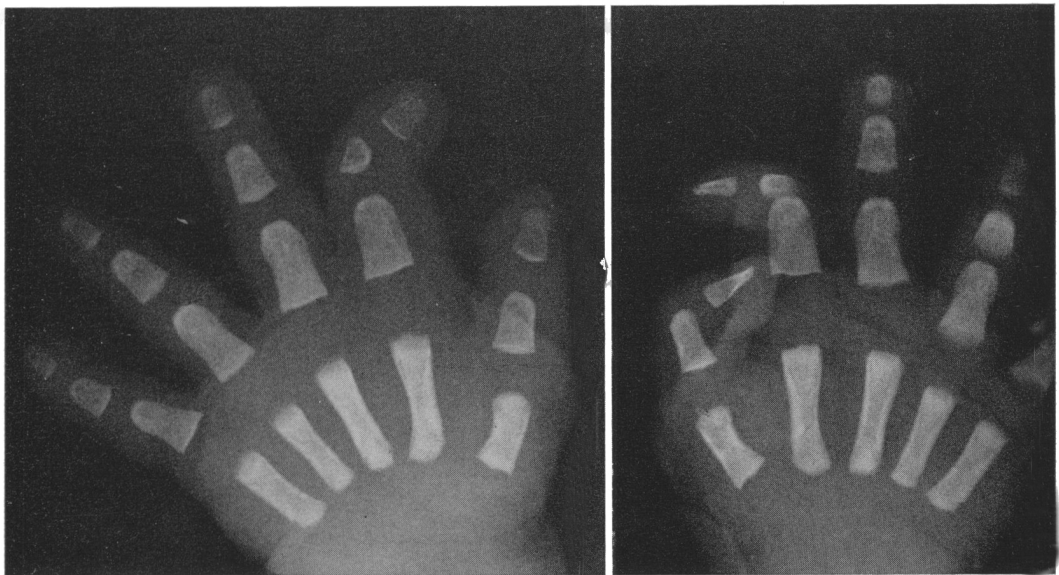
Roentgenograms of the hands of propositus at birth showing the typical dysplasia of middle phalanges of index fingers.
